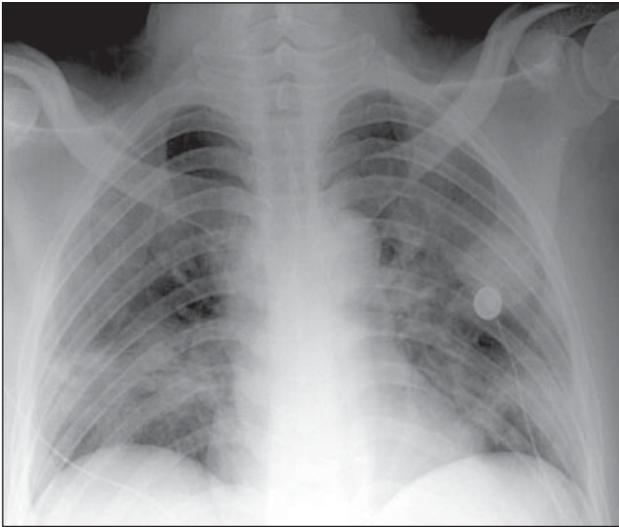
Frontal chest X-ray of a 44-year-old man with severe acute respiratory syndrome showing multi-focal ill-defined air space opacities in the periphery of the left mid-zone and both lower zones.
